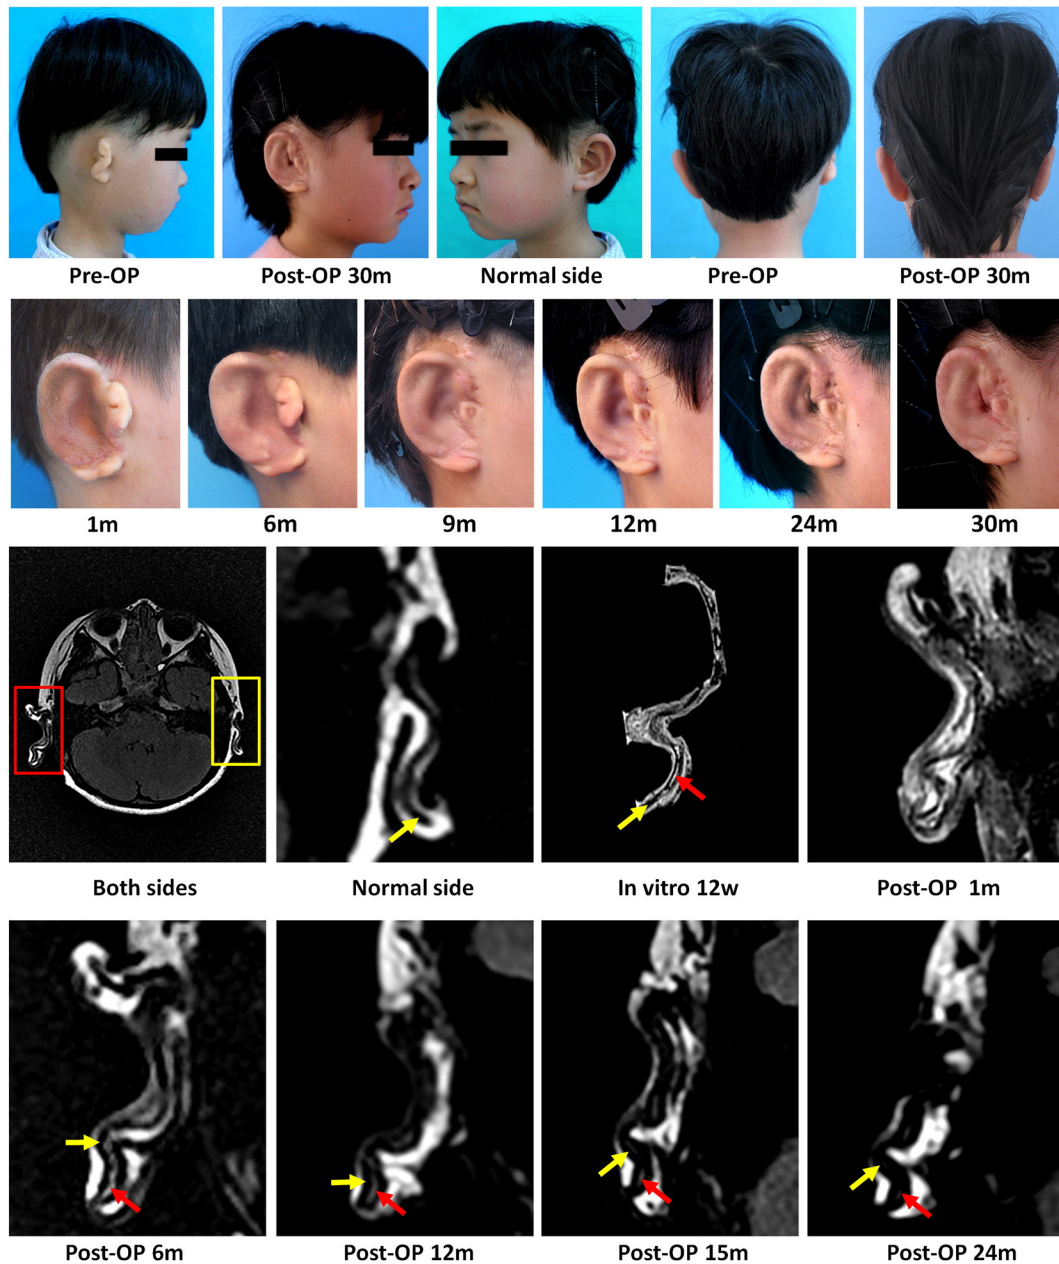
Post-implantation follow-ups. The pre-operated microtic ear showing a peanut-like structure. At two and a half years post-implantation, the reconstructed ear shows typical auricular features with helix, anti-helix, and cavum conchae, largely symmetrical to the healthy side. Post-implantation assessment at different time points shows the signs of gradual shape recovery, where only blunt ear structures are observed at the 1st and the 6th months post-implantation. Relatively clear ear features with helix, anti-helix, and cavum conchae structures gradually appeared at 9, 12, 24, and 30 months post-implantation. MRI examination reveals an obvious sandwich structure of the ear framework with cartilage (low signal, yellow arrows) surrounding the PCL core region (red arrows). PCL core region signals are difficult to distinguish from other tissue signals at early stage (Post-OP 1 m; a result of tissue edema) and present a gradual decreased trend with increased implantation time (Post-OP 6–24 m). Pre-OP: pre-operation; Post-OP: post-operation.
